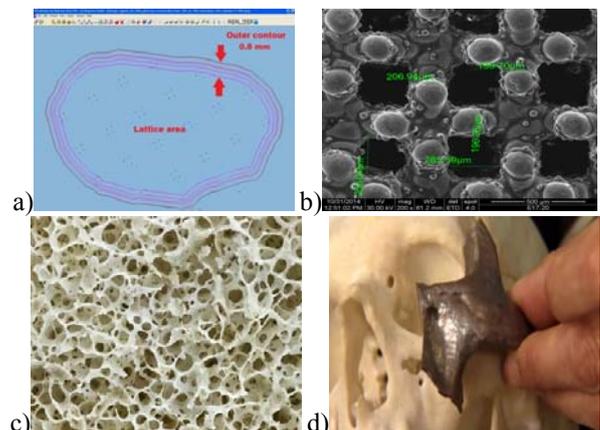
a) 3D cross section of A_b implant with 0.8 mm outer contour and lattice structure inside, b) SEM image with internal lattice structure (200 x magnifications), c) Cross section of human trabecular bone, d) A_c implant after grit-blasting by alumina and ultrasounds cleaning
